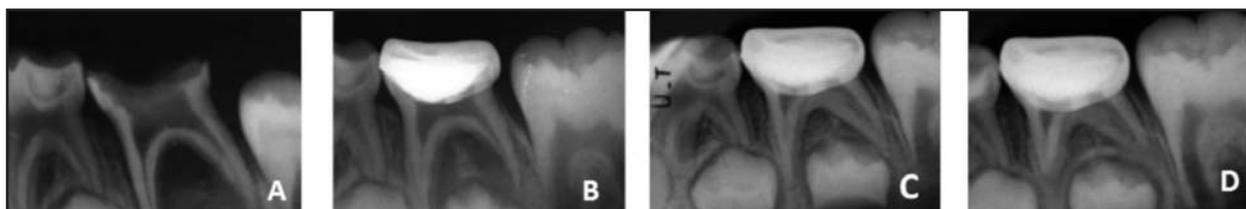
Successful LSTR 3Mix-MP in a lower left second molar with carious lesion involving pulp and interradicular radiolucency. A: Initial image. B: X-ray. 6 months postoperative: reduction in interradicular radiolucency area and presence of new bone formation. C-D: X-ray. 12 - 18 months postoperative: complete resolution of bone lesion.
